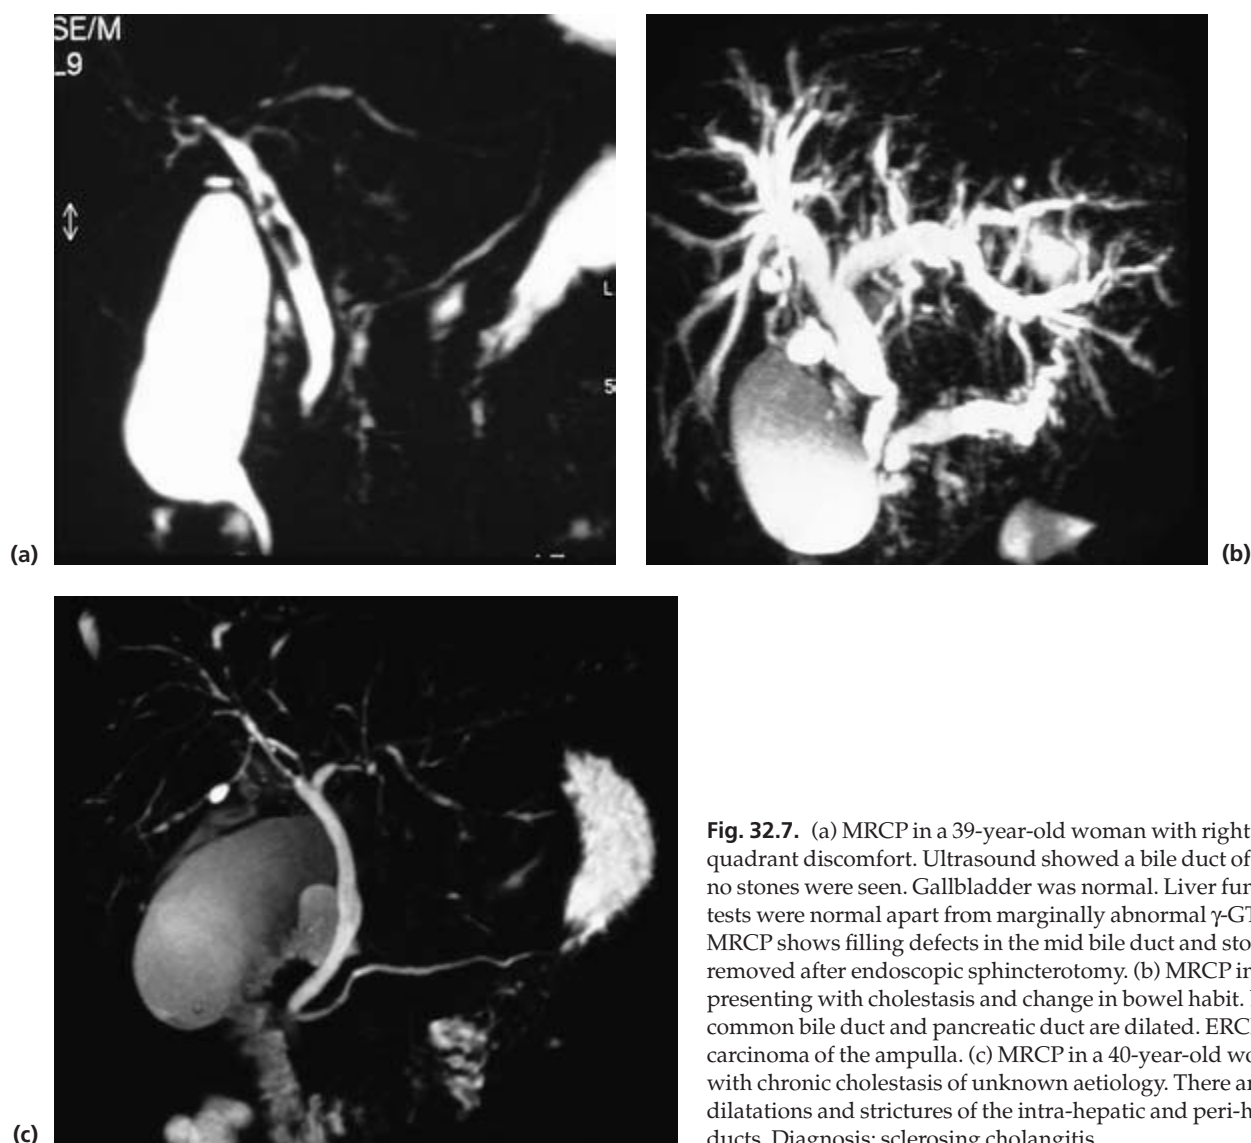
(a) MRCP in a 39-year-old woman with right upper quadrant discomfort. Ultrasound showed a bile duct of 1 cm but no stones were seen. Gallbladder was normal. Liver function tests were normal apart from marginally abnormal γ -GT. The MRCP shows filling defects in the mid bile duct and stones were removed after endoscopic sphincterotomy. (b) MRCP in a patient presenting with cholestasis and change in bowel habit. Both the common bile duct and pancreatic duct are dilated. ERCP showed carcinoma of the ampulla. (c) MRCP in a 40-year-old woman with chronic cholestasis of unknown aetiology. There are dilatations and strictures of the intra-hepatic and peri-hilar bile ducts. Diagnosis: sclerosing cholangitis.
